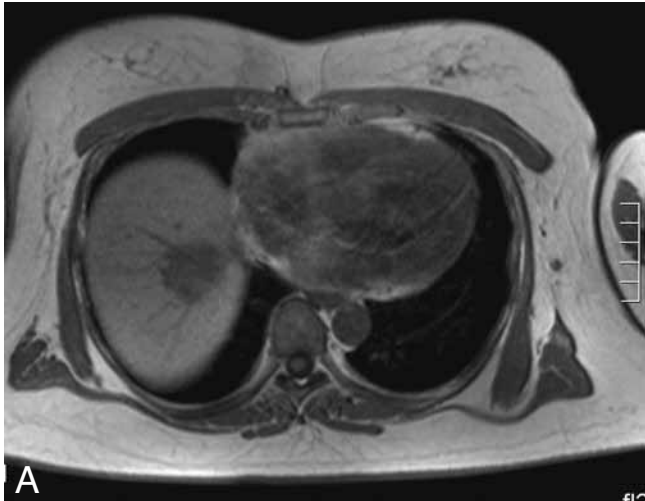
Unenhanced MRI of colon cancer metastasis. A. Lesion is hypointense on the T1-w GRE image. B. Metastasis shows moderate hyperintensity on the fat-suppressed T2w TSE image. C. The diffusion-weighted image with a high b-value of $600 \text{ mm}^2/\text{s}$ demonstrates typical high signal of metastasis due to restricted diffusion in the lesion.
